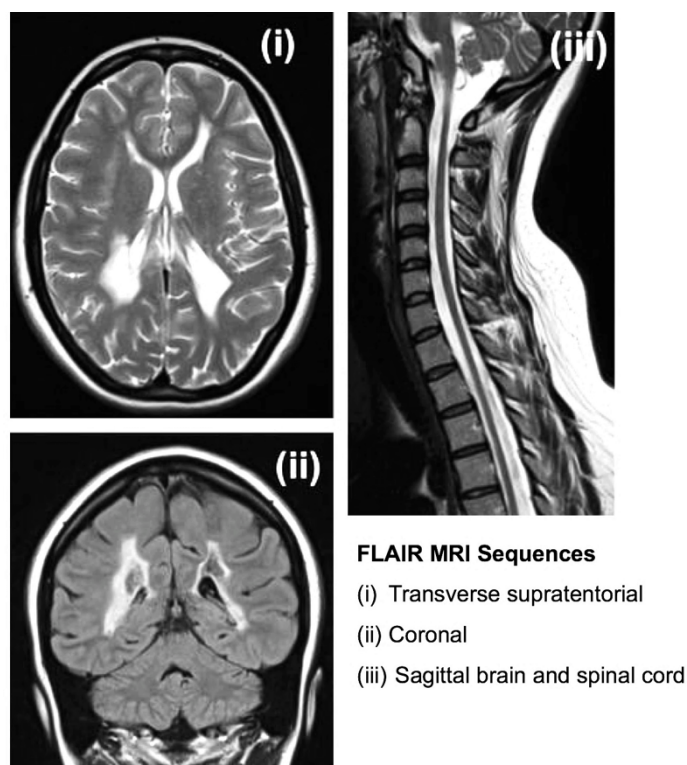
T2- FLAIR MRI sequences of the brain and spinal cord.
